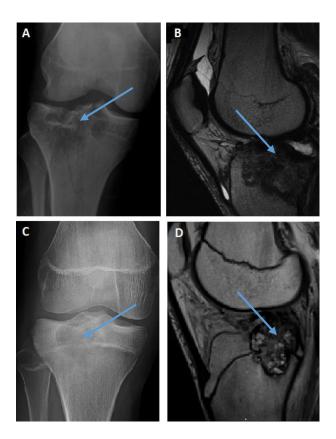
A) Plain X-ray and B) MRI (T2 weighted, sagittal view) of CCCS in the proximal tibia versus C) plain X-ray and D) MRI (T2 weighted, sagittal view) of chondroblastoma in the proximal tibia. Figure 13A and B are adapted from Zhang, Diagnostic Cytopathology, 2021.
